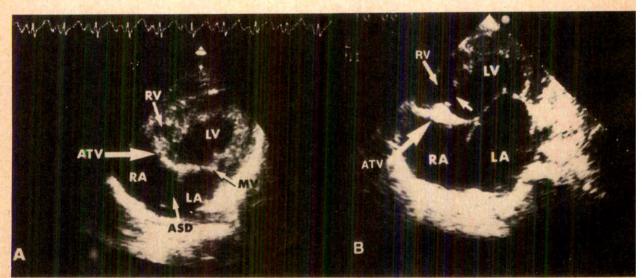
Subcostal 4-chamber 2-dimensional echocardiographic views of the heart in 2 children with tricuspid atresia. Note dense band of echoes representing atretic tricuspid valve (ATV) (large arrows) overlying the right ventricular (RV) cavity, although part of the ATV covers the left ventricular (LV) cavity. The left atrium (LA) and right atrium (RA) are also shown. A, an atrial septal defect (ASD) is seen, whereas, in B, there is a ventricular septal defect (small arrow). These echocardiographic figures demonstrate that the atretic tricuspid valve is related to the right ventricle. MV = mitral valve.
